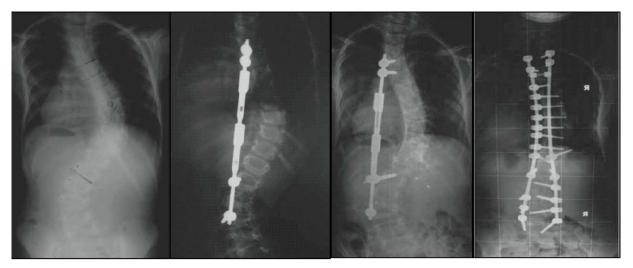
Preoperative postero-anterior radiograph of 7-year old with infantile idiopathic scoliosis showing 62° curve (first). Postoperative radiograph of single TGR system showing 30° major curve (second). Postoperative radiograph showing 40-fold improvement of curve (third). Postoperative postero-anterior radiograph following fusion procedure (fourth).¹⁶
